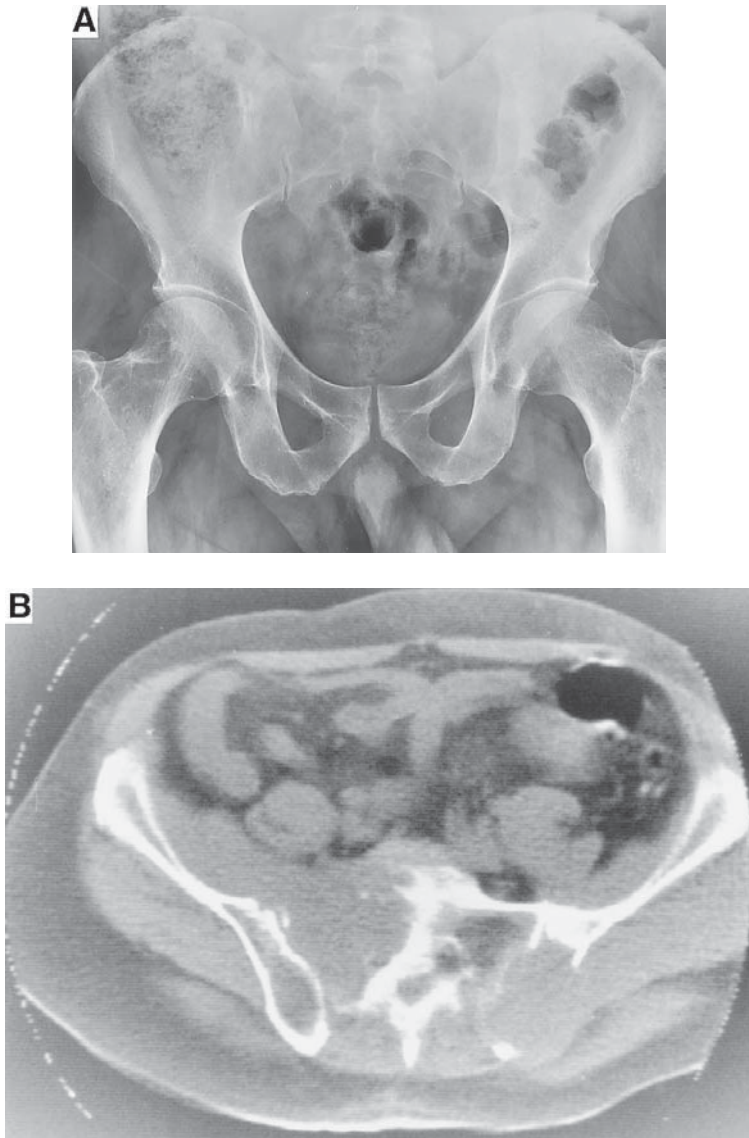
Plain X-ray (A), interpreted as normal, of a patient complaining of pain in his pelvis. A CT scan (B) showed a lytic metastasis with an associated soft tissue mass.
